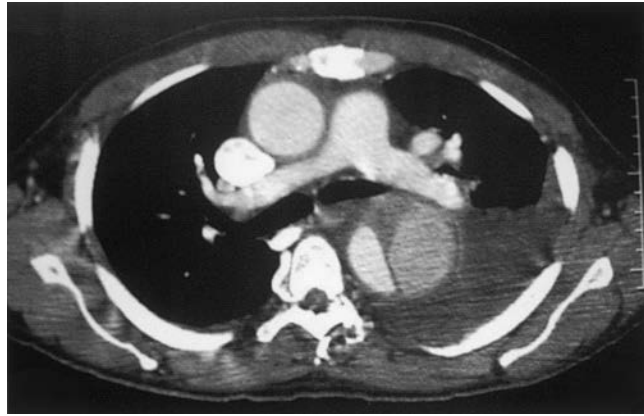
Axial chest CT image of a patient with acute type B aortic dissection in a thoracoabdominal aortic aneurysm. An intimal flap is seen in the descending thoracic aorta with different contrast enhancement of the true (smaller) lumen compared with the false (larger) lumen. The ascending aorta is not involved. A left pleural effusion is noted.
